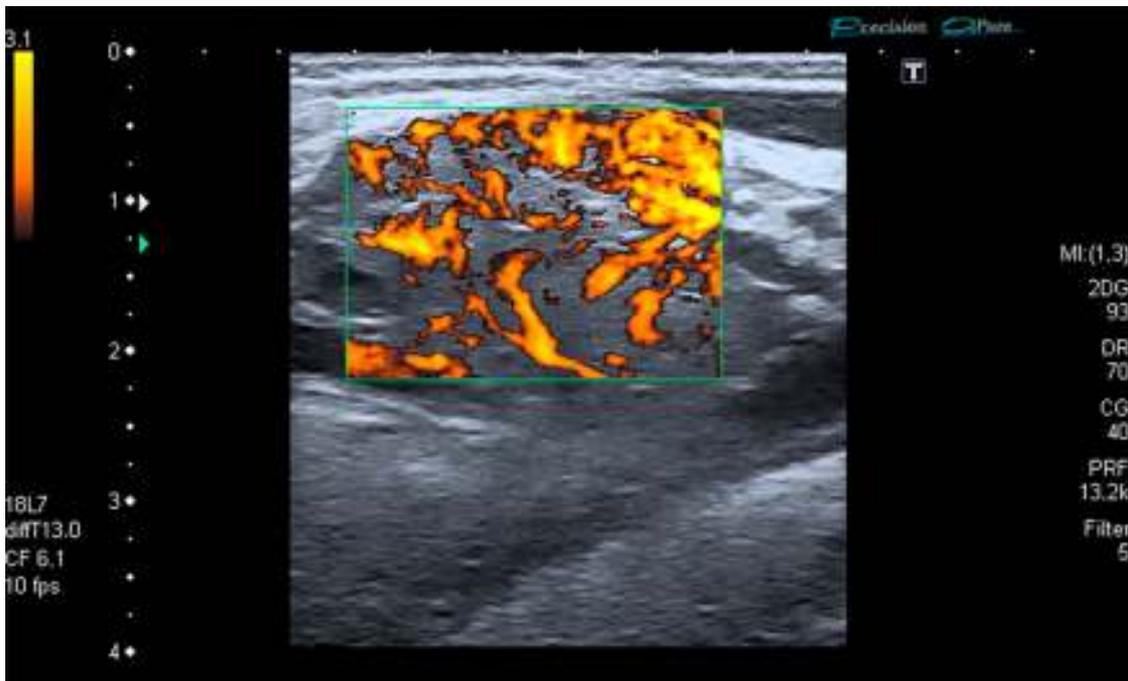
Color Doppler image showing the hypervascularity of the highly heterogeneous lesion, findings that rule out malignancy.
